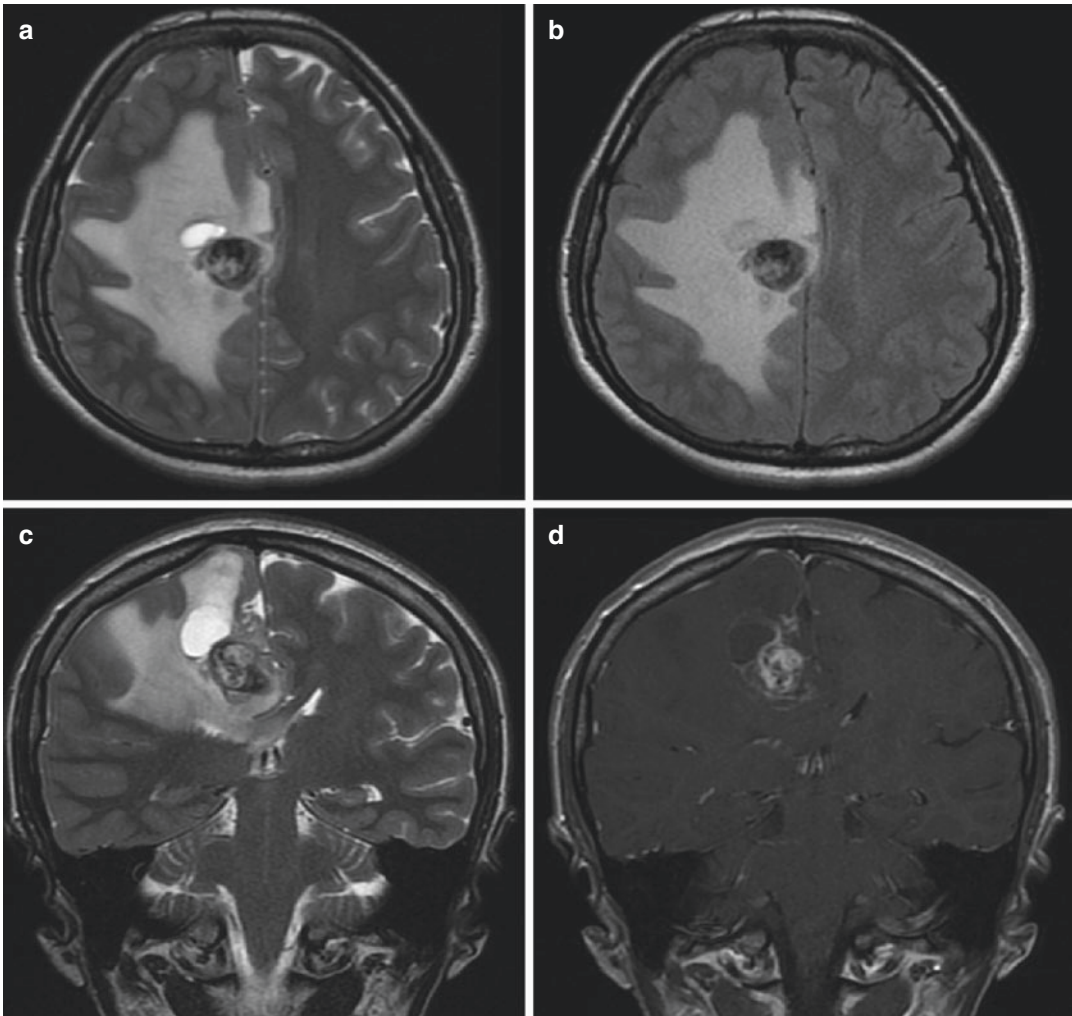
Neoplastic edema and mass effect. Axial T2-weighted (a) and FLAIR-weighted images (b) and coronal T2-weighted (c) and gadolinium-enhanced T1-weighted images (d) show right frontal metastatic lesion of breast cancer with large amount of perilesional
